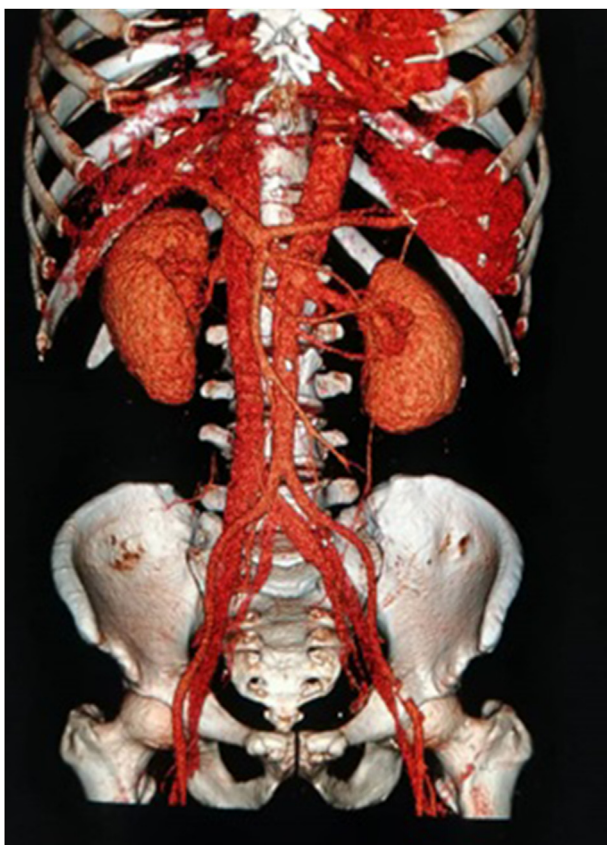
CT reconstructed view showing filling defect at left external iliac artery.
